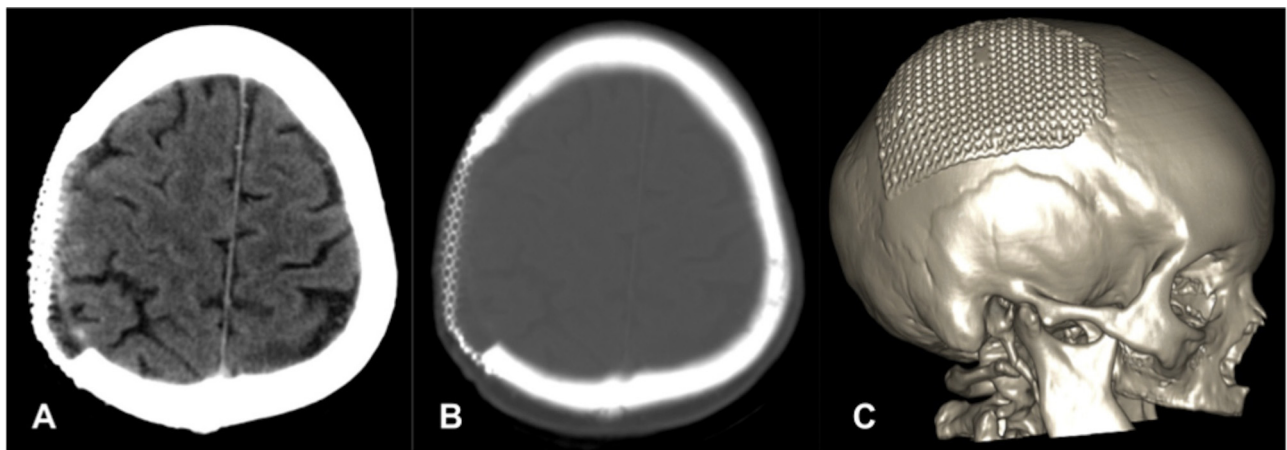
A 10-month postoperative head CT scan showing the right parietal craniotomy with the reconstructive titanium mesh and absence of residual lesions. A: brain window; B: bone window; C: 3D reconstruction.
